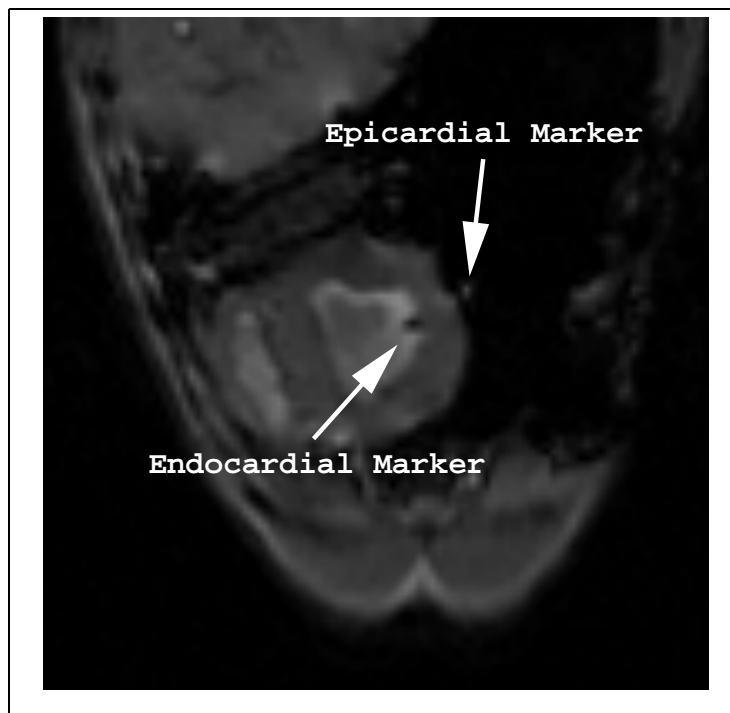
MRI image with endocardial and epicardial markers.
